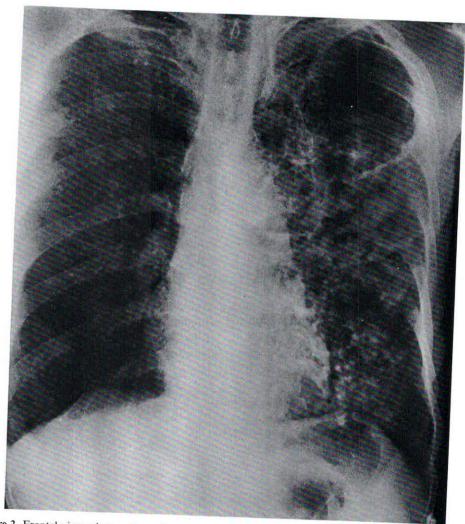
Frontal view, chest radiograph, showing extensive tuberculosis causing respiratory failure.
